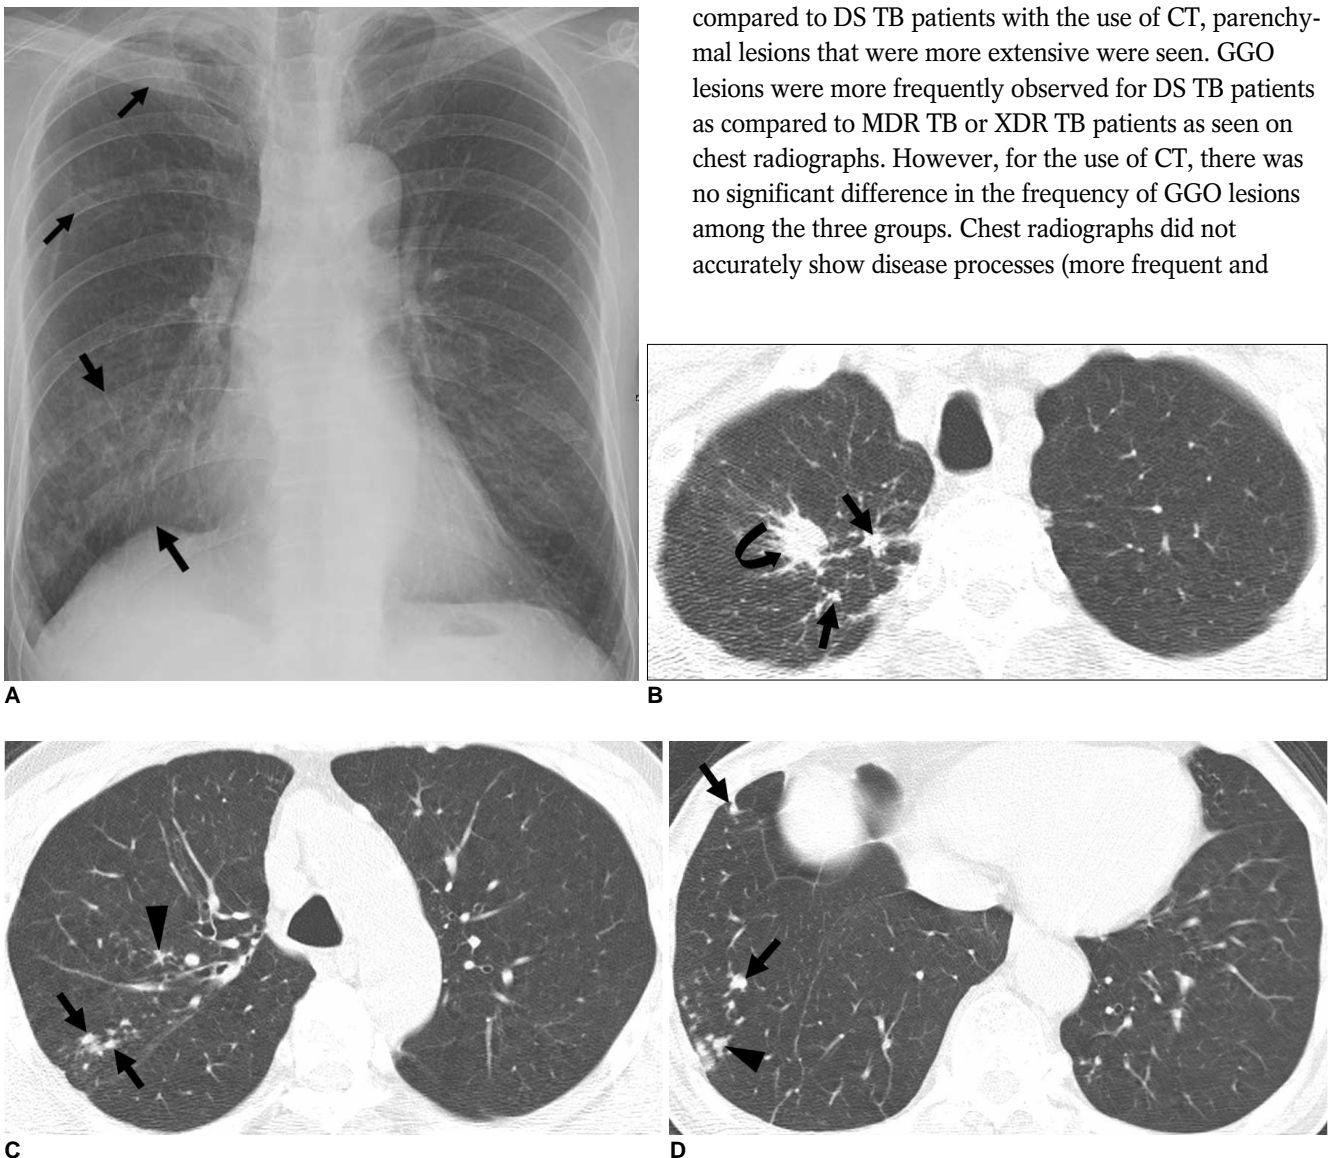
Findings for drug-sensitive tuberculosis in 70-year-old man. A. Posterior-anterior chest radiograph shows small nodular lesions (small arrows) in right upper lung zone and variable-sized nodules and reticulo-nodular lesions (large arrows) in right lower lung zone. B-D. Transverse CT (2.5-mm section thickness) scans obtained at levels of great vessels (B), aortic arch (C) and liver dome (D), respectively, show small nodules (arrows), tree-in-bud signs (arrowheads) and nodules (curved arrow) in right upper lobe and right lower lobe.
